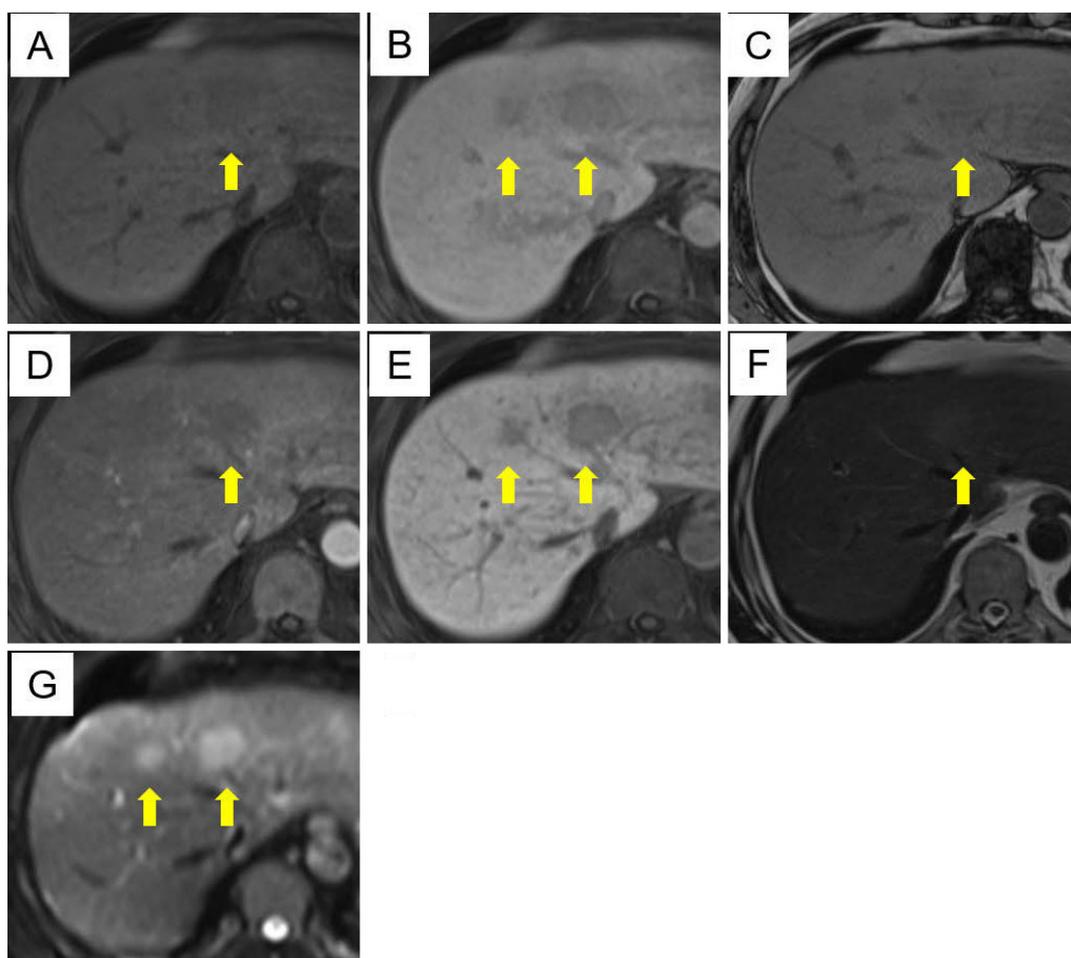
Abdominal MRI findings at referral to our division. (A) T1-weighted image, (B) T1 early phase, (C) T1 portal phase, (D) T1 late phase, (E) T1 hepatocyte phase, (F) T2-weighted image, (G) diffusion-weighted image. The hepatic nodules have a low signal intensity on T1 imaging with very weak contrast enhancement and slightly high signal intensity on T2 imaging. The nodules are distinguished clearly on diffusion-weighted imaging.
